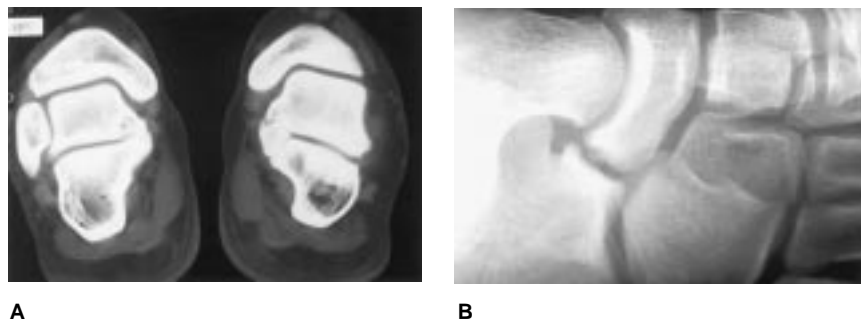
Examples of coalition. A, A CT scan of a bilateral solid talocalcaneal coalition in a 25-year-old patient. Coalition usually takes place at the level of the sustentaculum tali. B, An oblique radiograph shows a fibrous talonavicular coalition in a 22-year-old patient.
